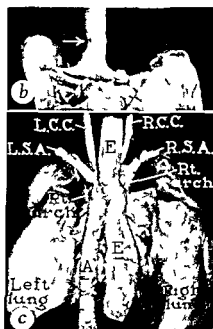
a b and c—From the case described on preceding page a Roentgenogram of the thorax b The trachea and major bronchi There is indentation of the trachea (point of arrow) caused by pressure of the right aortic arch against the trachea c Thoracic organs from behind The right arch had been divided surgically near its junction with the descending aorta The ends of the divided right arch have retracted exposing the esophagus (E) where it had been compressed RSA = right subclavian artery RCC = right common carotid artery LCC = left common carotid artery LSA = left subclavian artery A = descending aorta
